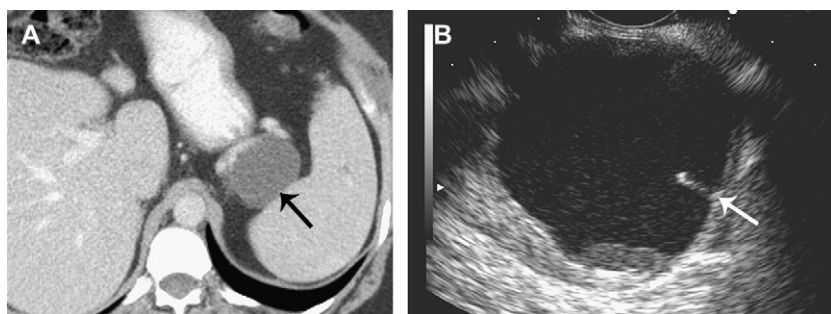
Forty-seven-year-old woman who has a mucinous cystic neoplasm (cystadenoma)—surgically proven. (A) Contrast-enhanced CT shows a spherical mass (arrow) arising from the tail of the pancreas. A thin septum is visible near the dependent wall of the cyst. (B) EUS demonstrates the cystic mass. The septum (arrow) and debris or mural nodularity along the dependent wall are more evident than on CT.
